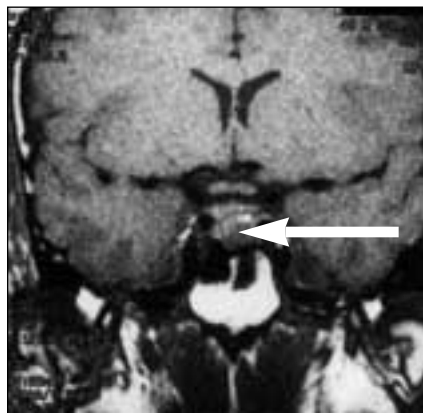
Midline coronal section of precontrast MRI of head showing pituitary adenoma (arrow).
